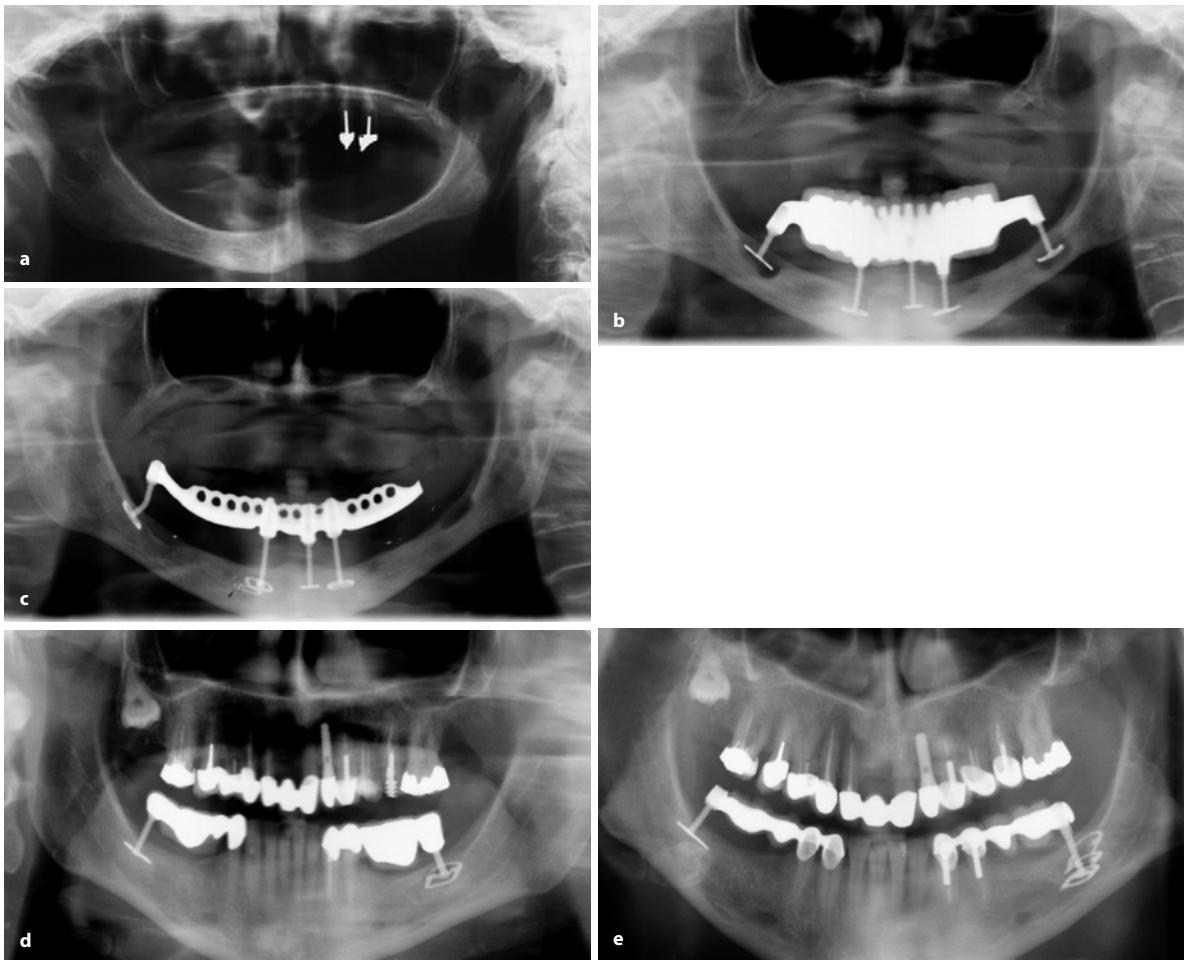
a Preoperatively, the patient presented with pronounced mandibular atrophy. The two maxillary teeth had still permitted chewing for many years, but only on the left side. As a result, the mandibular midline had drifted massively to the left. The right horizontal branch of the mandible was stretched in this process. b Discrepancies of this magnitude obviously require so much remodelling in both jaws that the two distal BOI implants could not preserve their osseointegrated state. Nevertheless, this first restoration had remained in function for 5 years. By contrast with the situation in Fig. 9.24d,e, osseointegration of the distal BOI implants was certainly not the optimum (although not absent completely), and the patient's oral hygiene habits were extremely unsatisfactory. For these reasons, larger areas of mineralization deficiencies could become established, with the bridge ultimately being supported mostly by the anterior implants. c BOI therapy and concurrent equilibration of the masticatory function had the result that the midline could now be repositioned such that the left horizontal branch of the mandible could increase substantially in length and the difference in height between the two branches levelled. The tensions this created were again incompatible with osseointegration of the BOI implant in the region of tooth 37. The implant was removed, and the bridge was left supported by four BOI implants. We assume that after 1 or 2 years, a new implant could be safely integrated in the same region and connected to the bridge. Note the massive morphological changes between the baseline situation and the radiograph taken after 7 years of wearing fixed restorations, with increasingly equilibrated masticatory function. It was not until many years had passed and the two maxillary premolars had been extracted that this masticatory function could be adjusted properly. Completely edentulous jaw quadrants with a few contralateral teeth can be the reason for unilateral mastication patterns. d Two posterior segments were inserted first in this patient. Because the pontics had not been reduced on the basal side of the bridge, the implant bars fractured. Contrary to our normal usage, the load-transmitting disk of the left BOI implant was not removed; instead, a new disk was inserted directly below the old disk. (It was possible to re-use the first bridge as a temporary restoration. This resulted in a random relative positional reorientation inside the bone. A few months later, the left implant fractured again. The third disk was again inserted below the second one). e The panoramic overview radiograph taken at a later occasion clearly shows an increasing distalization of the disks left in place in the third quadrant as the disks were drifting and changing location along with the bone substance
